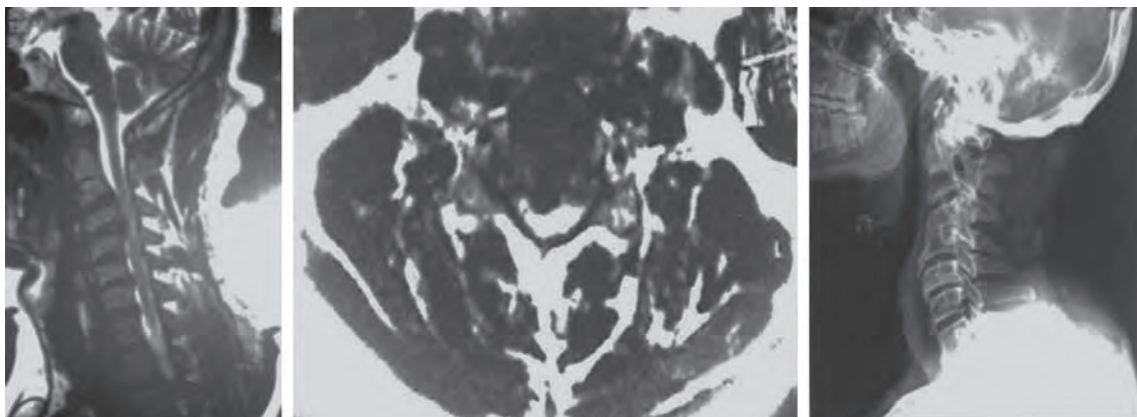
Sagittal and axial view MRI showing C4-5 disc prolapse. Patient underwent anterior cervical discectomy C4-5. X-ray after 1 year showing fusion
